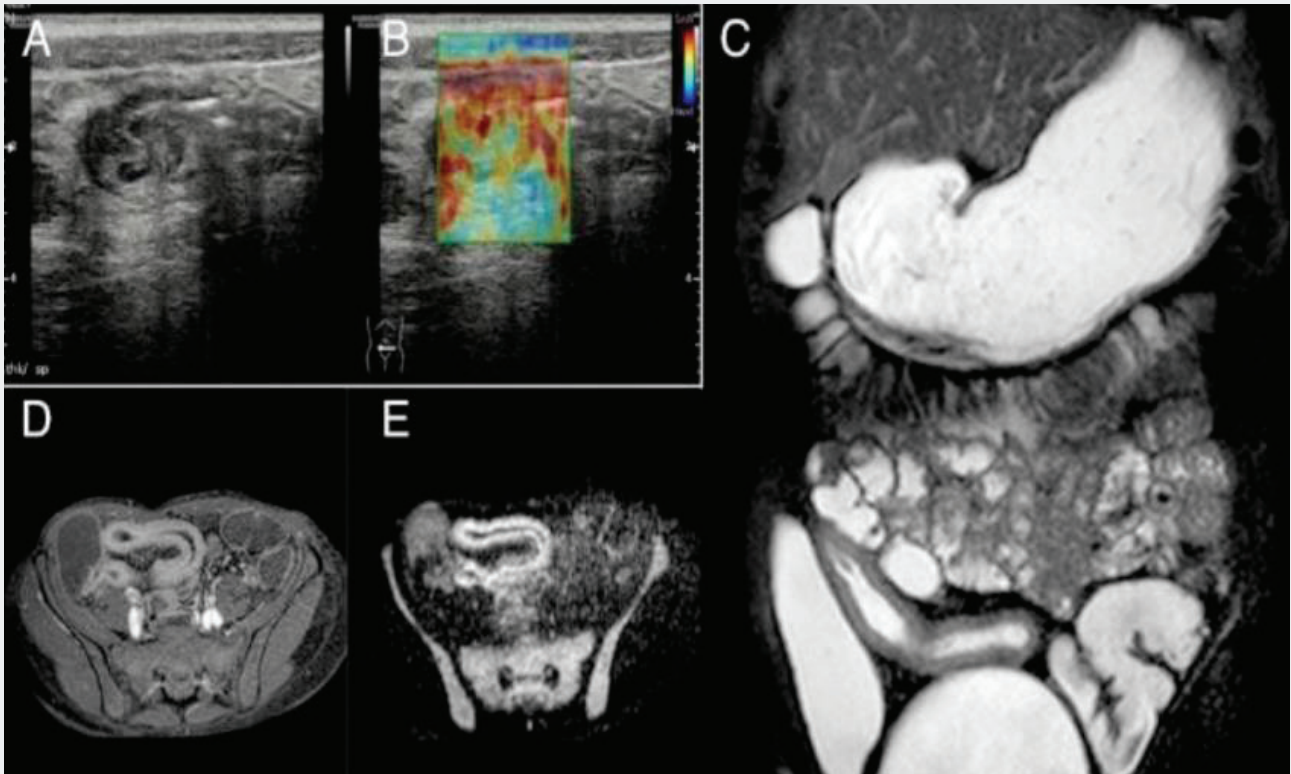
Longitudinal US-scan of the last ileal loop in a 33-years old male shows wall thickening with prominence of submucosa and hyperechoic appearance of perivisceral fat. The gray scale (A) findings and US-SE (B) aspect performed at this level are suggestive for of active inflammation pattern. The MR study (C, D and E) confirmed these suspicions: T2-weighted coronal view revealed hyperintensity of the bowel wall, T1-weighted axial post-contrast showed stratification of the bowel wall, DWI with 800 b-value showed hyperintensity of the bowel wall and an aspect of the last ileal loop very similar with US findings.
